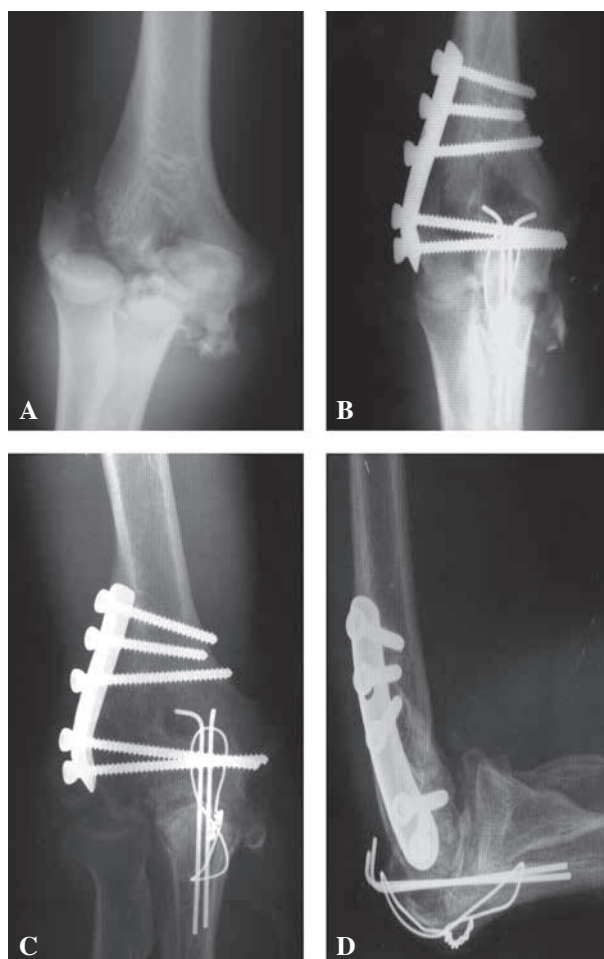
Patient 5. lateral elbow dislocation with fracture of lateral humeral condyle (AO-Type-B1.3). (A). Pre-operative X-rays. (B). Postoperative radiographs. (C-D). Results at 4.17-year follow-up.
